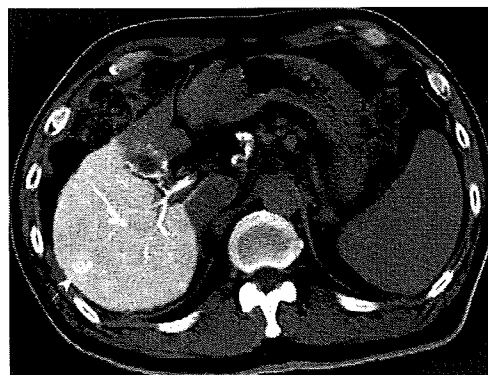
Heterogeneous hyperattenuation at CTA (arrow).
